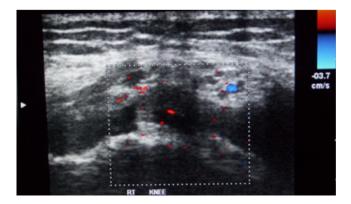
Colour Doppler ultrasound of the right knee showing four hot spots with synovial Doppler score equal to 2.
